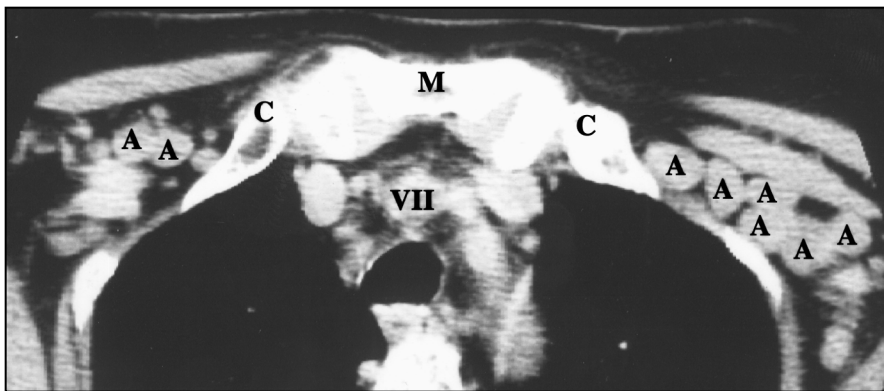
67-year-old man with lymphoma. Axial contrast-enhanced CT scan of neck through level just below top of manubrium (M) shows medial clavicle (C) on each side. Level VII node is seen in superior mediastinum. Multiple axillary nodes (A) lie lateral to ribs on each side of upper chest.
